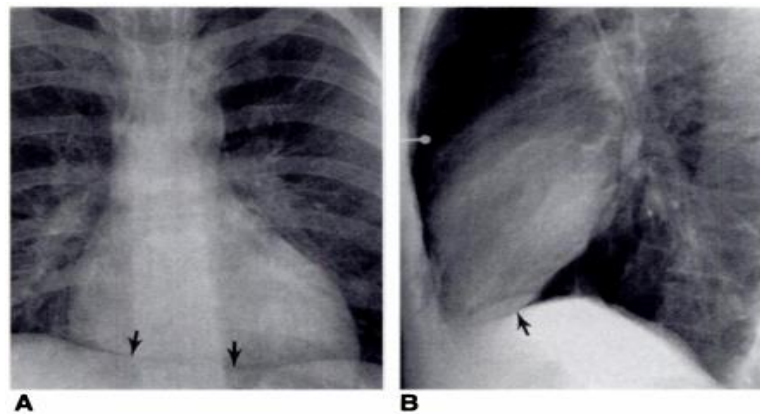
A, PA Thorax radiograph taken during expiration shows a thin band of air (arrow) between the heart and the diaphragm, making the diaphragm visible where normally obscured by the heart. This finding is known as the continuous diaphragm sign. B, Lateral chest radiograph, air outlines the superior surface of the left hemidiaphragm (arrow), which is usually obscured by the liver. This finding is the continuous diaphragm sign.^{1,2}
